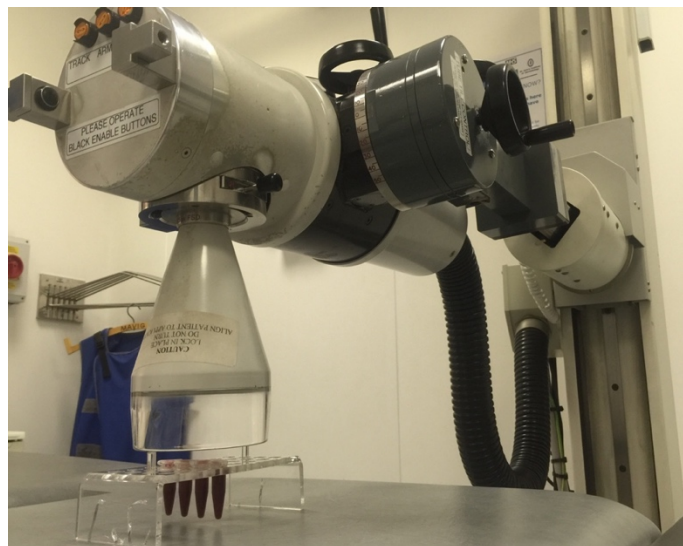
In vitro irradiation of blood samples using Darpac 2000 (Gulmay Medical) x-ray unit
